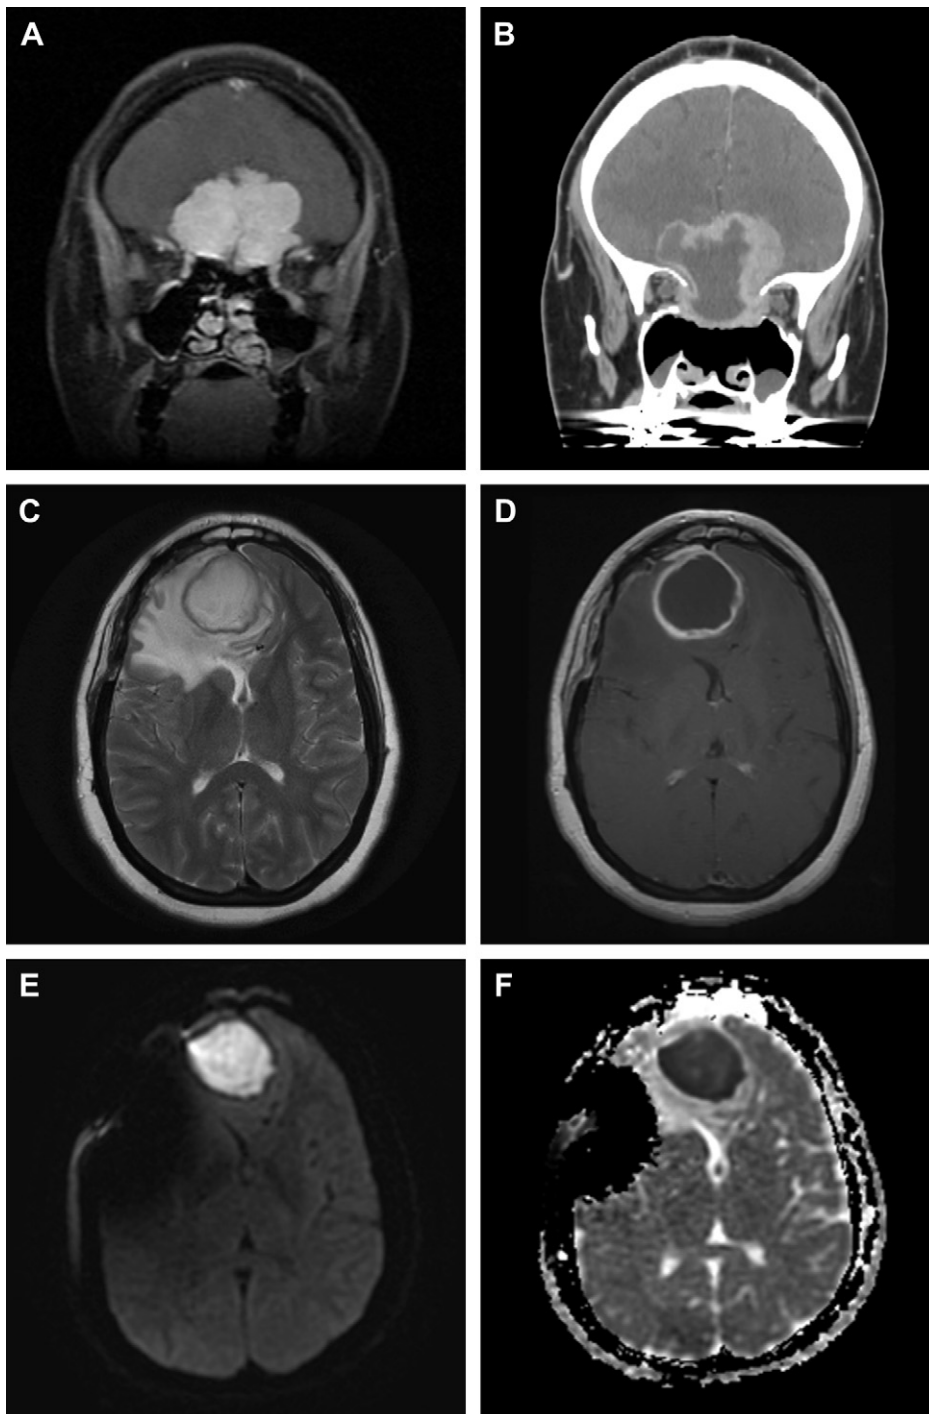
A 36-year-old woman with a history of headaches. (A) Coronal T1 postcontrast fat-saturated sequence demonstrates an enhancing extra-axial mass along the floor of the anterior cranial fossa, characteristic of an olfactory groove meningioma. (B) Reconstructed coronal CT postcontrast image demonstrates partial resection of the mass that was done via a staged expanded endonasal and subfrontal approach. Postoperative course was complicated by recurrent frontal sinusitis and CSF leak requiring surgical repair. (C, D) Axial T2 and T1 post-contrast images demonstrate a large right frontal abscess with a characteristic T2 hypointense enhancing capsule. There is extensive surrounding vasogenic edema and mass effect displacing the anterior falx cerebri toward the left. There is associated opacification of the frontal sinus related to chronic sinusitis. (E, F) Hyperintense signal on the diffusion-weighted image and hypointense signal on the ADC map within the mass are consistent with restricted diffusion and typical of pyogenic abscess. Cultures from the abscess grew *Streptococcus milleri*. Susceptibility artifact in the right frontal region is from surgical hardware.
